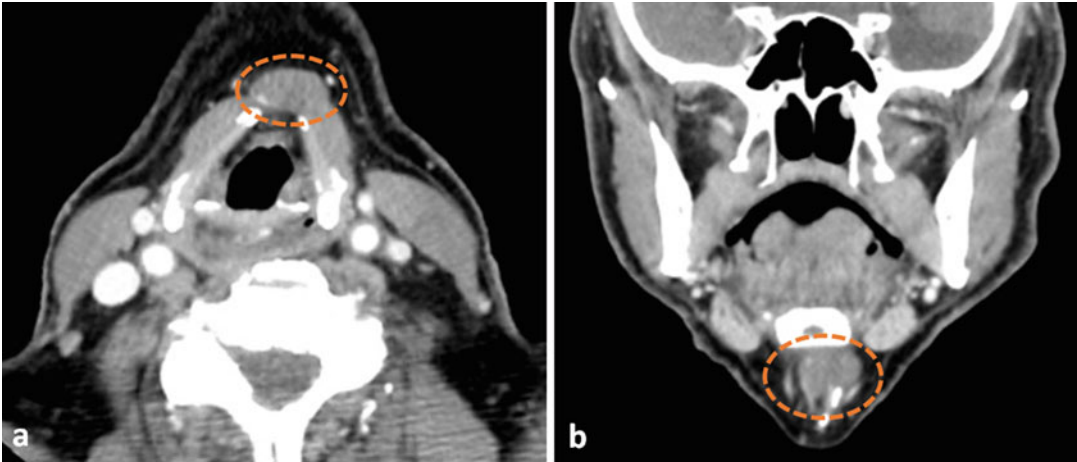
Thyroglossal duct cyst. Axial (a) and coronal (b) CT shows a 19 mm ovoid lesion in the position of an infrahyoid thyroglossal duct cyst (dashed orange oval)
